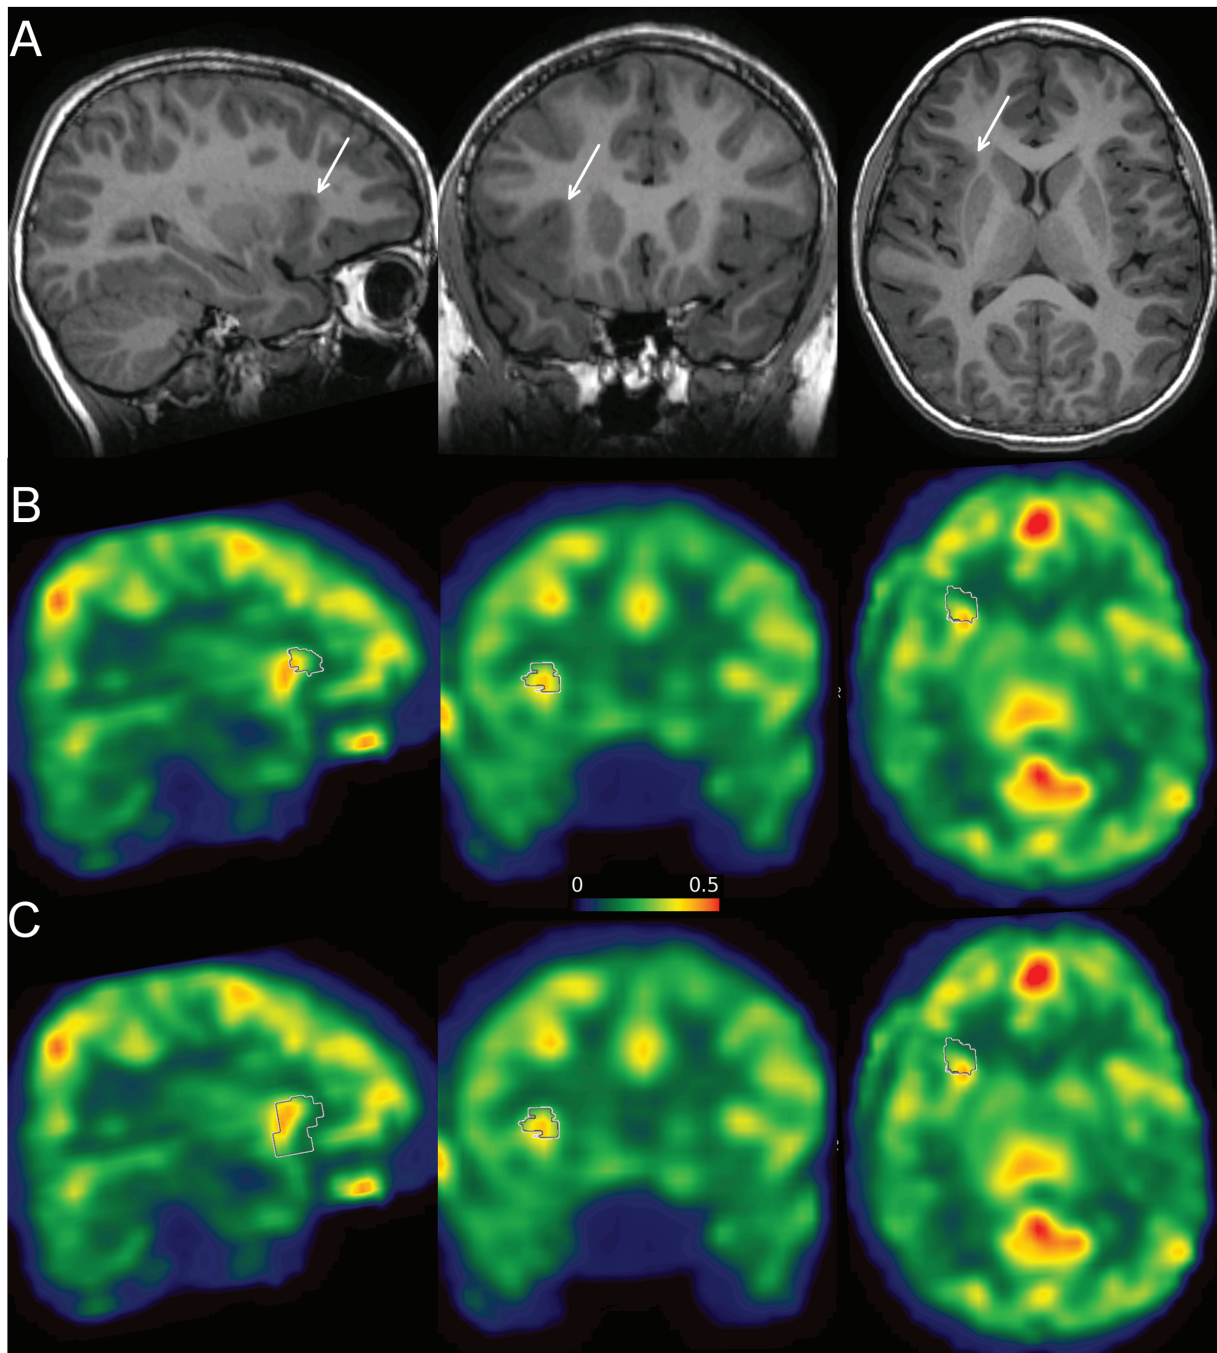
Lateralization of regional homogeneity (ReHo) in patient 4 (9 years old girl). (A) Preoperative T1-weighted image (sagittal, coronal, and axial planes), showing a subtle white matter-gray matter blurring (white arrows). (B, C) Preoperative ReHo maps (sagittal, coronal, and axial planes, color scale represents Kendall's coefficients of concordance) with planned to be resected region of interest (ROI; white contours in B) and positron-emission tomography (PET)-based ROI (white contours in C). Resected volume matches with a part of the high ReHo volume, whereas PET-based ROI almost entirely matches with the high ReHo volume.
